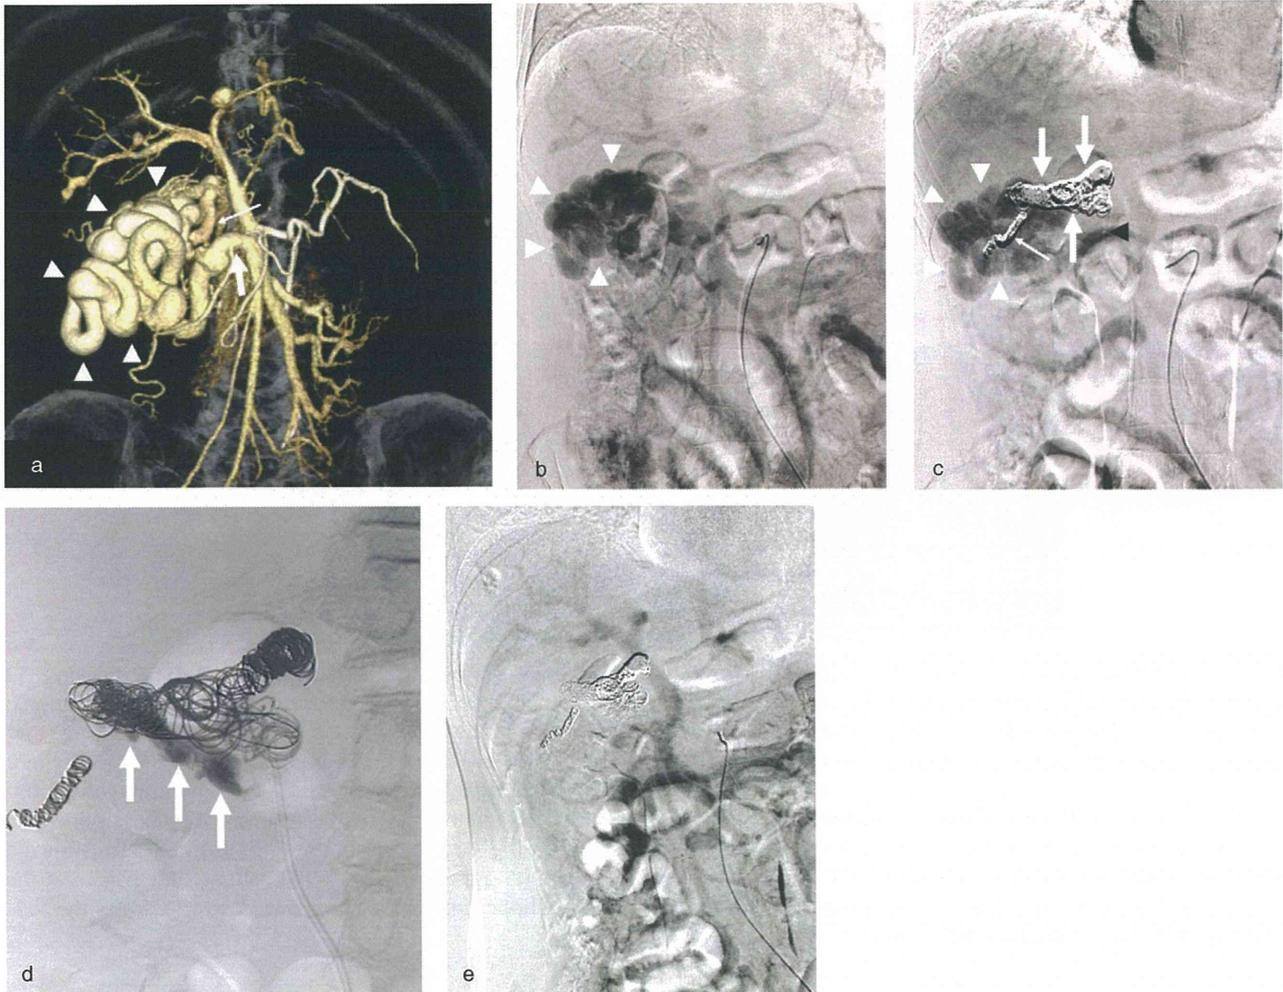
Percutaneous transvenous embolization (PTE) with coils and n-butyl 2-cyanoacrylate (NBCA) for a large superior mesenteric vein (SMV) inferior vena cava (IVC) shunt (patient no. 9). (a) 3-D image obtained by computed tomographic arterial portography via a superior mesenteric artery shows a large SMV-IVC (arrowheads) shunt. Large and small arrows indicate the inflow from an SMV and outflow to an IVC, respectively. (b) A superior mesenteric angiography shows a large SMV-IVC shunt similar to (a) (arrowheads). (c) A superior mesenteric angiography still shows an appearance of SMV-IVC shunt (white arrowheads) after placements of 25 microcoils at the main outflow vein to the IVC (large arrows) and 11 microcoils at the collateral vein (small arrow) via a right femoral vein using a 3-Fr microcatheter through a 5-Fr balloon catheter (black arrowhead). (d) NBCA-lipiodol mixture (5 mL; ratio 1:1) (arrows) was injected from a microcatheter under balloon occlusion to fill the gaps between the coils for a more complete blockage of the shunt. (e) A superior mesenteric angiography shows no appearance of the shunt after coils and NBCA embolization.
